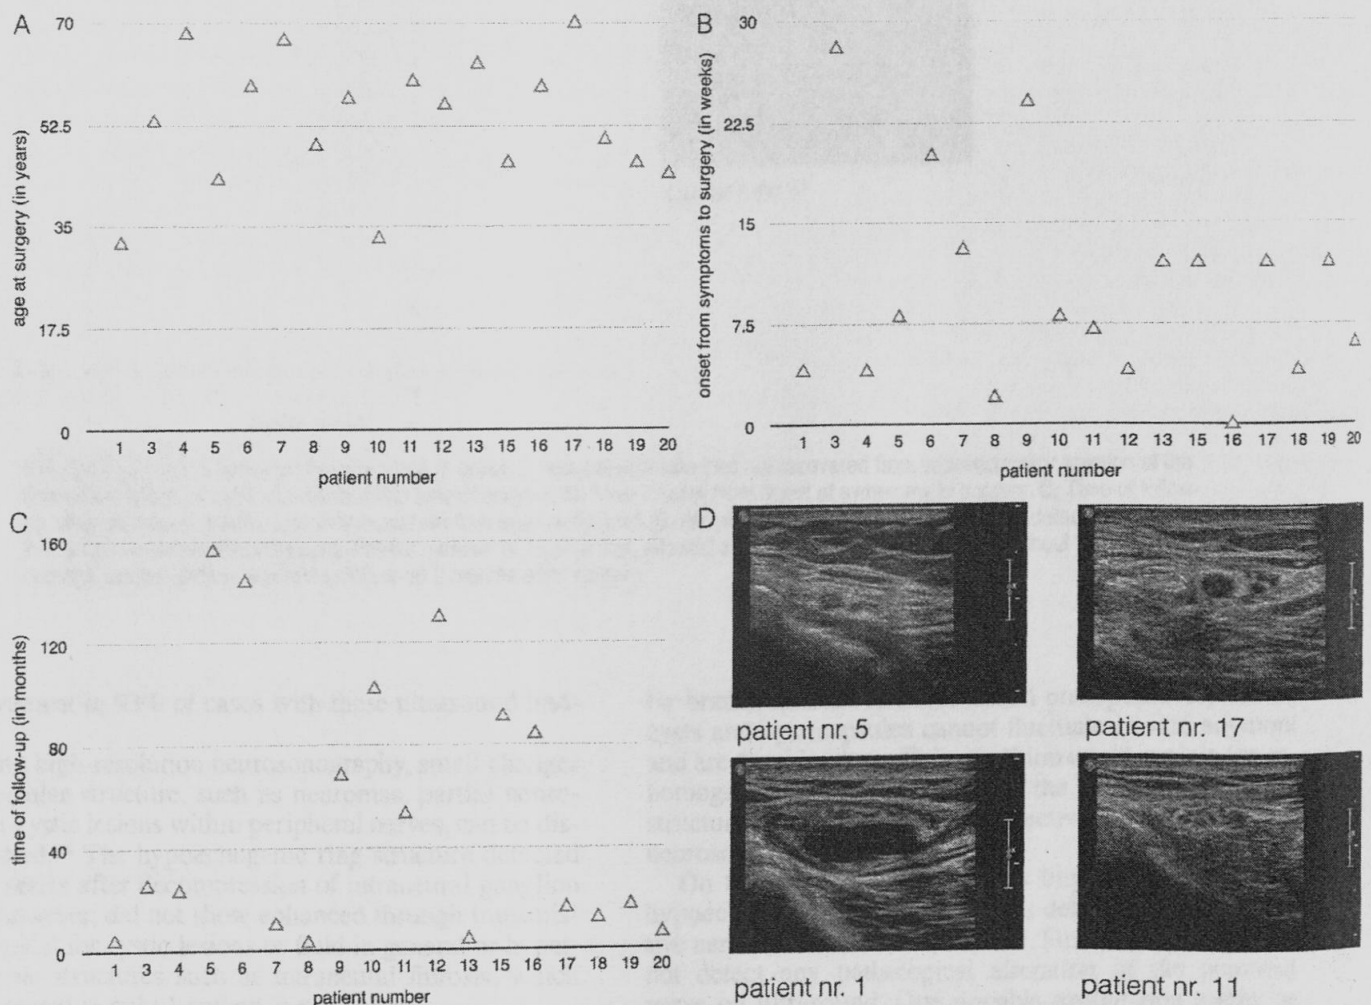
Demographic baseline characteristics of group 1, with patients who recovered from impaired motor function. A: Age of patients at the time of surgery. B: Time interval from onset of symptoms to surgery. C: Time of follow-up, when neurosonography and clinical examination were performed. D: Representative patient ultrasound images. Hypoechoic ring structure in postoperative neurosonography, which could be detected in 77% of the patient cohort, is shown in representative ultrasound images of patients 5 and 17. Patient 1 presented with a recurrent cyst but showed recovery as well. Patients 10, 11, and 16 showed regular fascicular structure in neurosonography postoperatively at the time of follow-up (shown in representative ultrasound image of patient 11). In patients 3 and 6, who developed neuropathic pain, no other alterations that could be responsible for pain were detected sonographically. Neurosonography showed only the hypoechoic ring structure. nr. = number.
